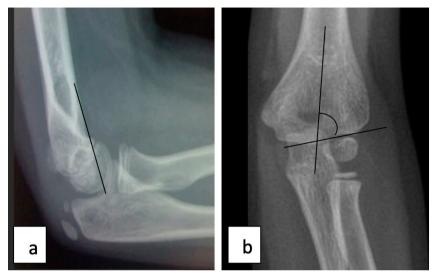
a) Normal elbow X-ray –lateral radiograph showing Anterior Humeral line (AHL) intersecting capitellum. b) AP radiograph showing Bauman's angle
